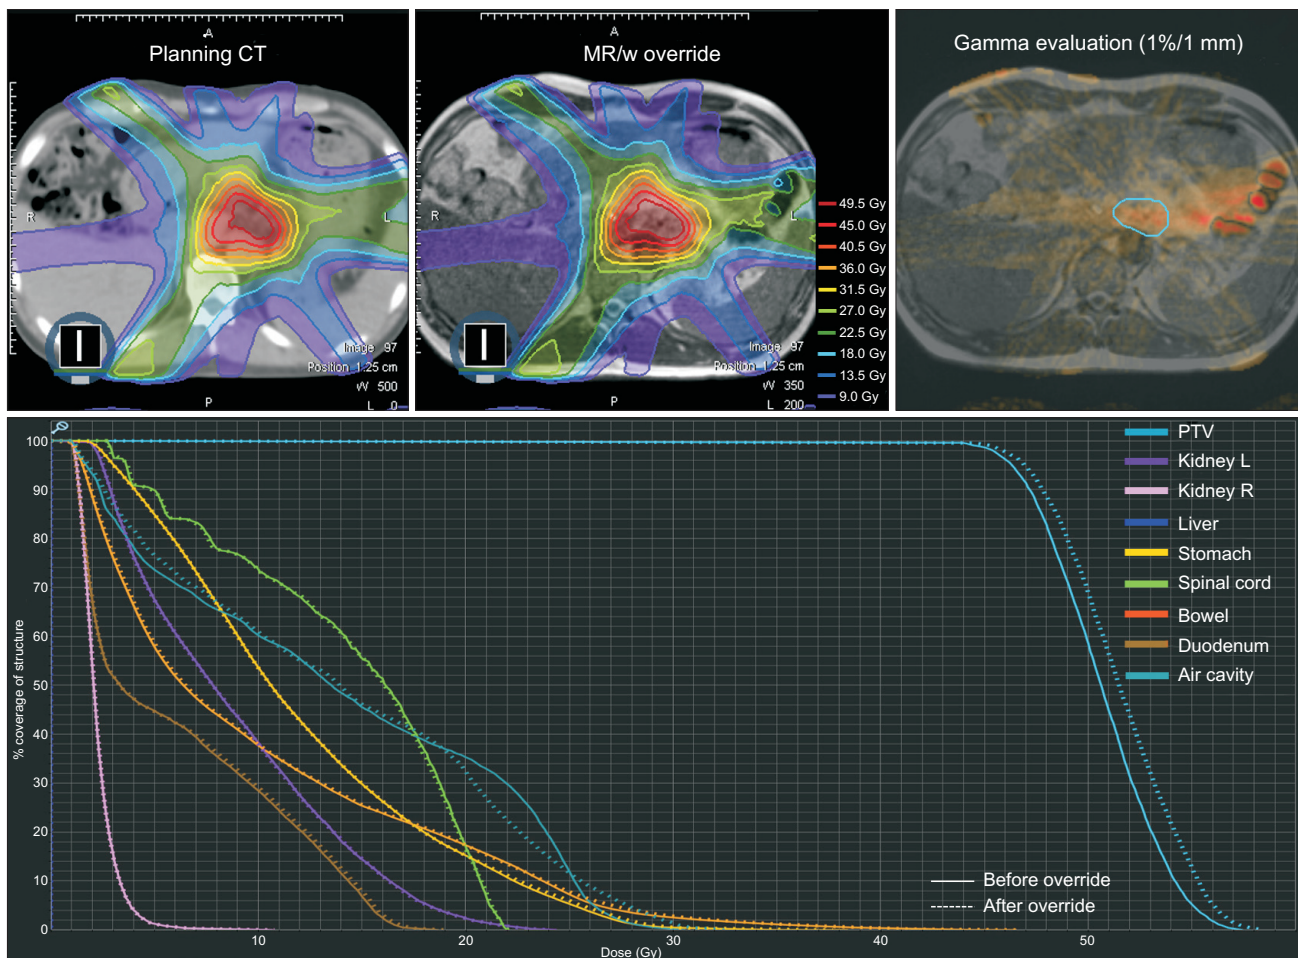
A pancreas magnetic resonance image-guided radiation therapy (MRgRT) example, with air pockets located near the planning target volume (PTV) and on the beam path. The calculated dose distribution before overriding the air pockets on planning computed tomography (CT) (top left), after overriding those on treatment MR (top middle), and the gamma map between two dose distributions (top right) are represented. Dose volume histograms (DVHs) of the PTV, kidney, liver, stomach, spinal cord, bowel, duodenum, and air pocket of MR are shown at the bottom. The dashed and solid lines represent the DVHs calculated from the plans before and after the electron density map override, respectively.
